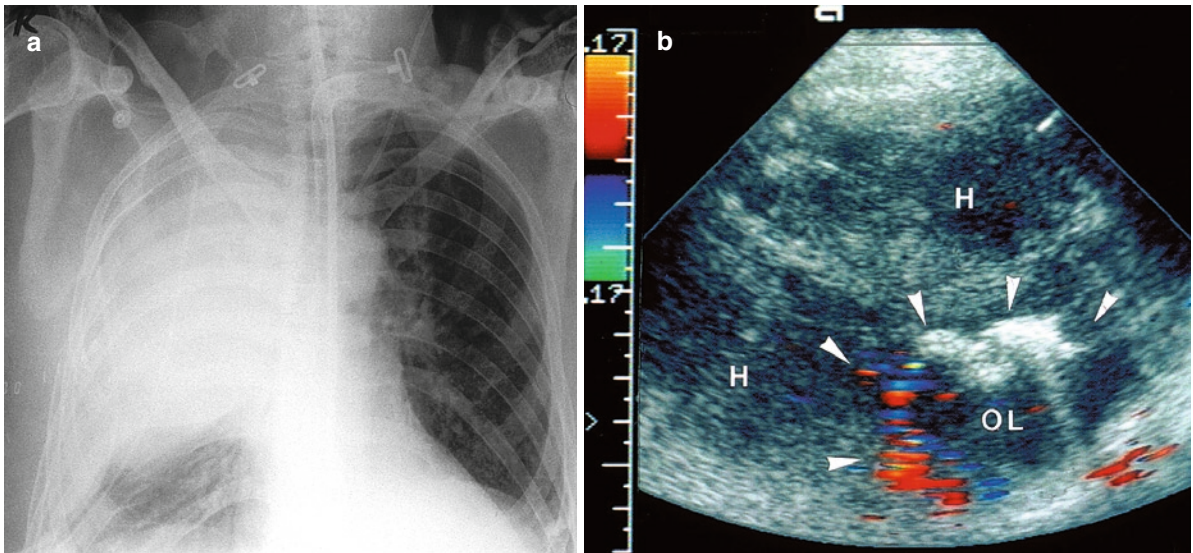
A 46-year-old woman with breast carcinoma. (a) Chest radiograph. Nearly complete opacity of the lung on the left side. (b) Sonography. The lateral intercostal transmission of the ultrasound beam on the left side shows a marked pleural
